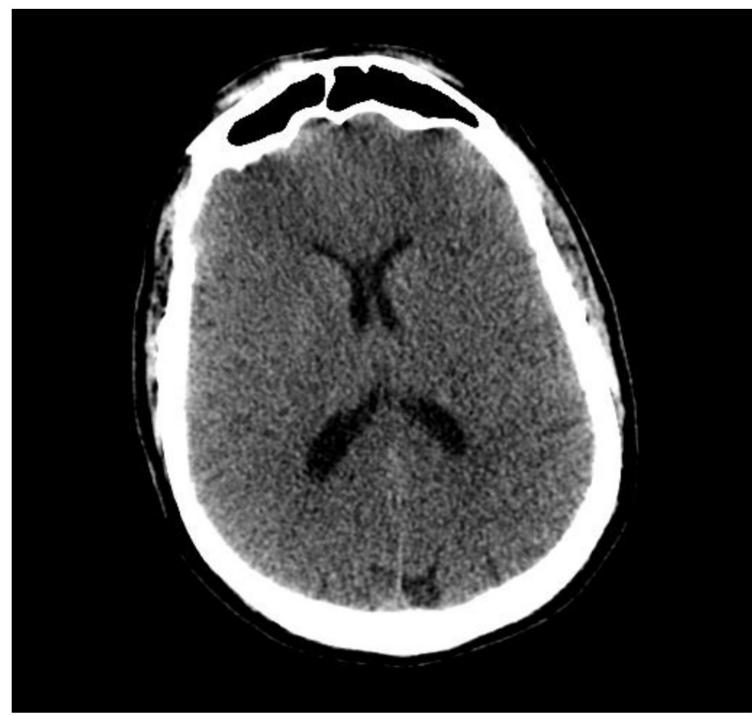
2 CT Head showing cerebral edema [elevated ammonia]
